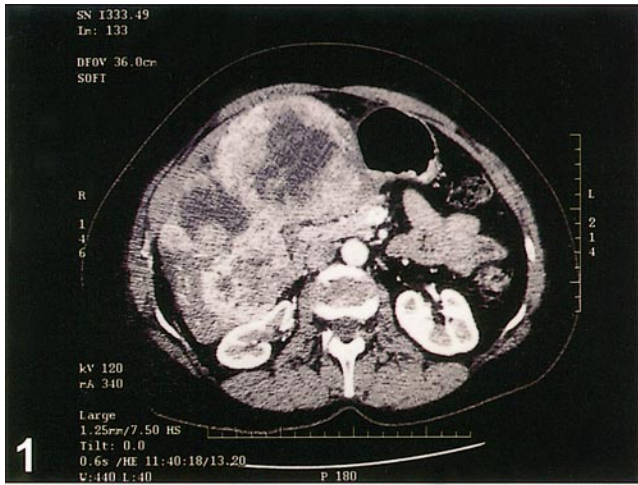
Computed tomographic image of the heterogenous, poorly circumscribed, right hepatic lobe mass demonstrating widespread replacement of hepatic parenchyma and large radiolucent zones of necrosis.
